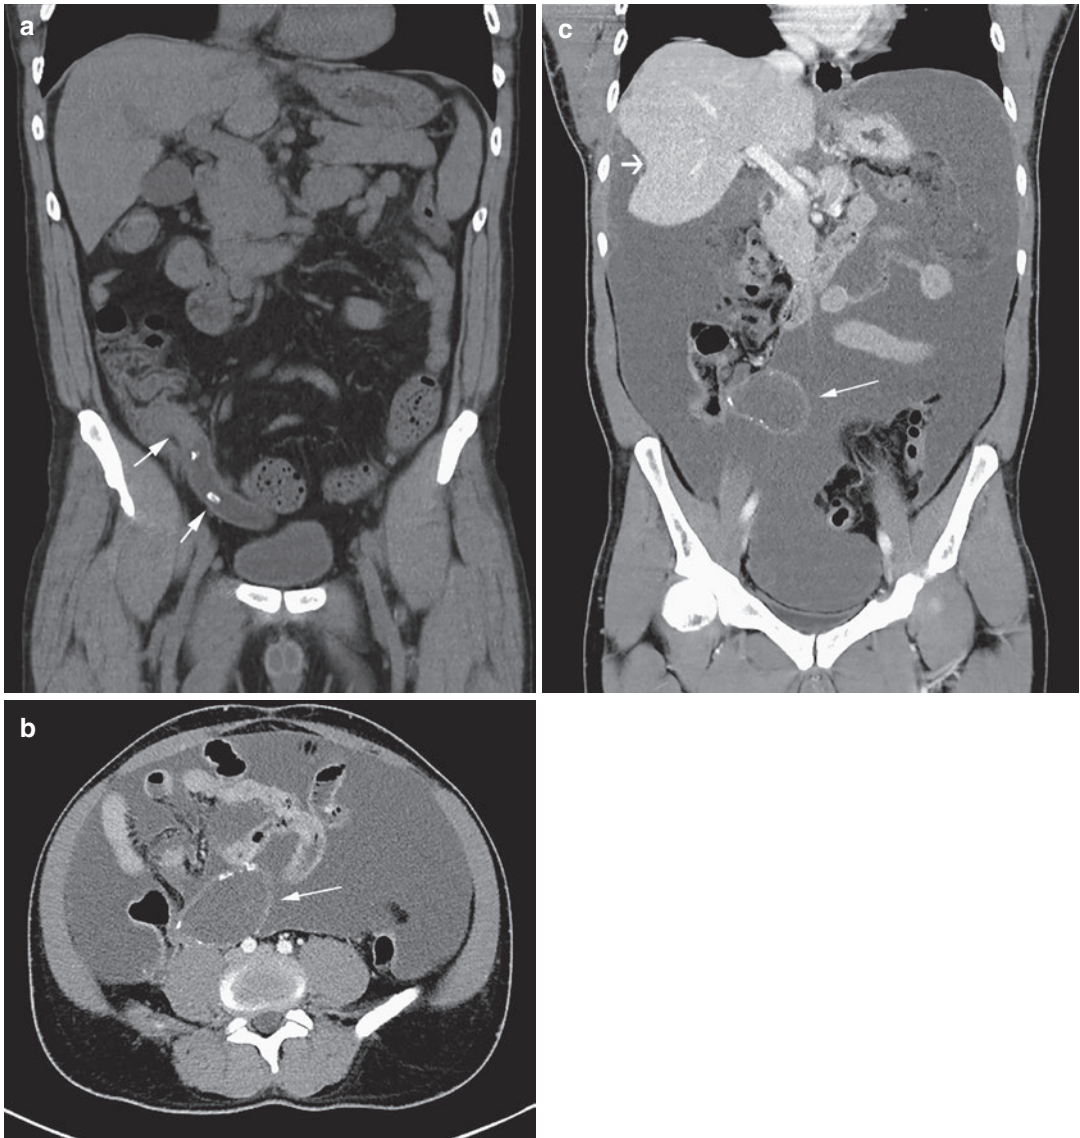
(a) A 42-year-old male with nonspecific abdominal pain. Non-contrast coronal CT depicts a fluid-distended appendix in the right lower quadrant with internal calcifications (*arrow*) and soft-tissue density at the base (*arrow*). Patient subsequently underwent right hemicolectomy with pathology consistent with mucinous adenocarcinoma of the appendix. (b) 56-year-old male presented with increasing abdominal distension. Axial CT
